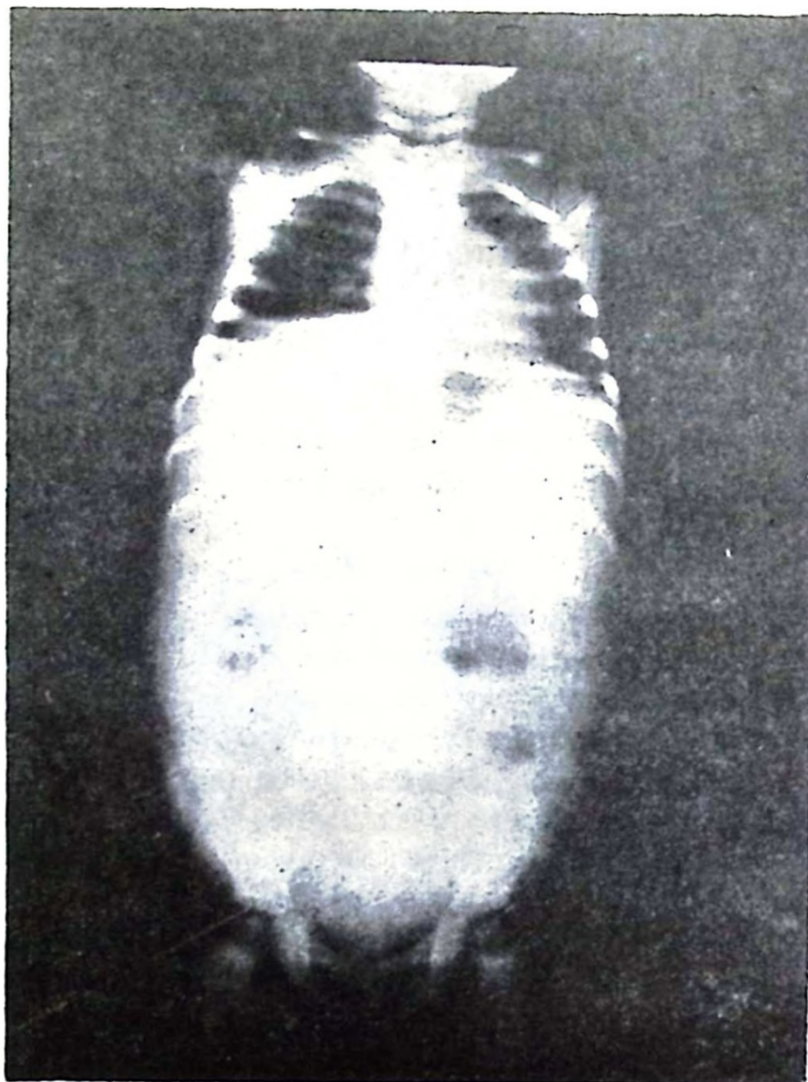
Roentgenogram showing elevation of the right cupula of the diaphragm.
